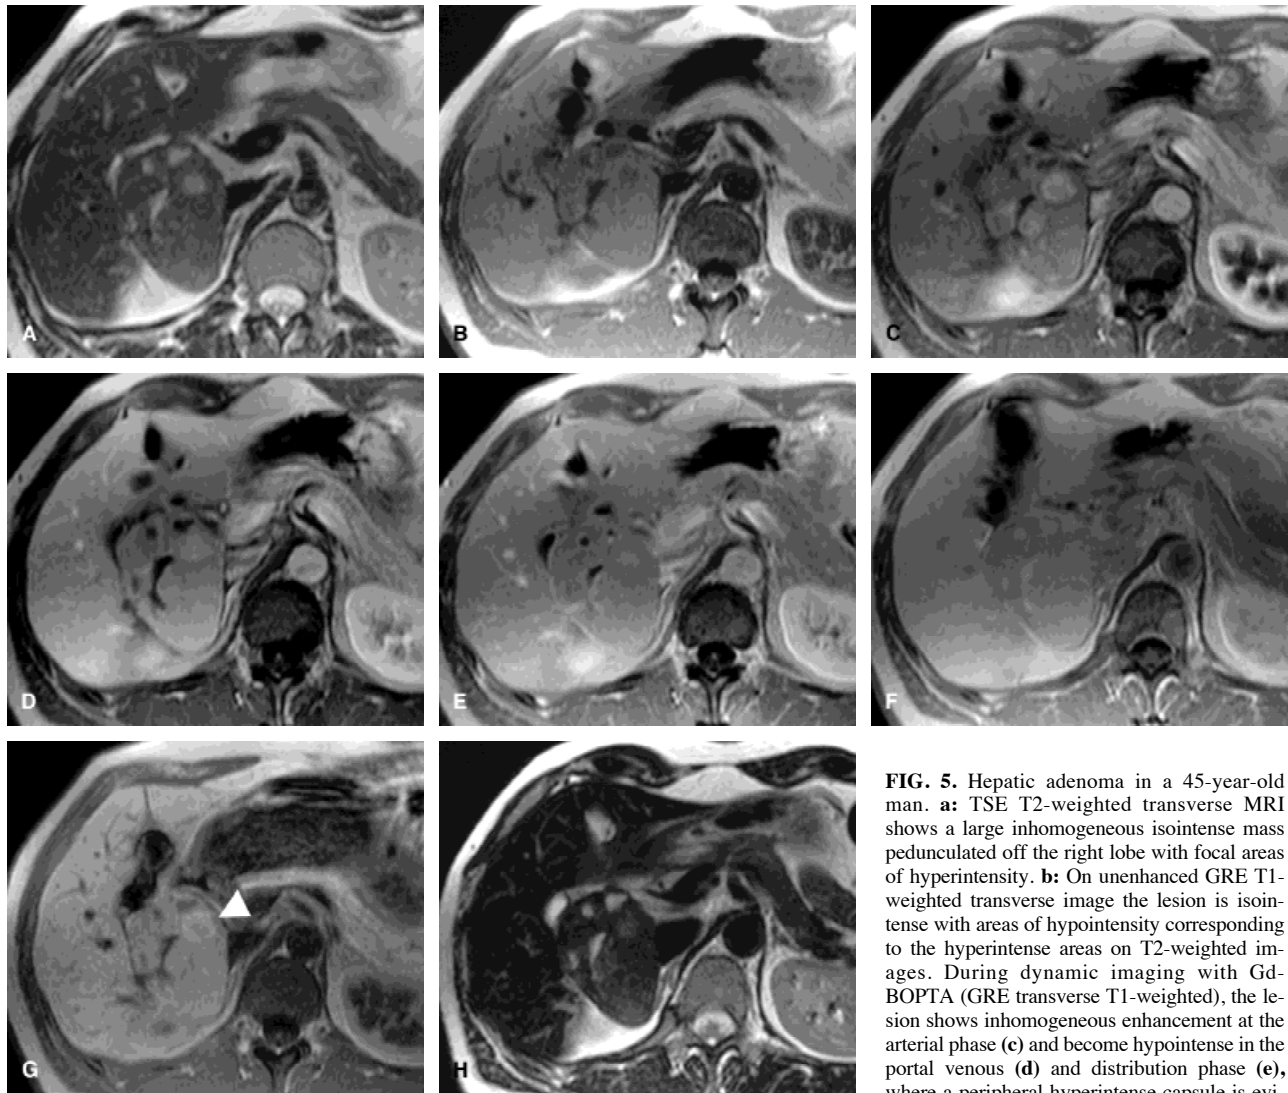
Hepatic adenoma in a 45-year-old man. a: TSE T2-weighted transverse MRI shows a large inhomogeneous isointense mass pedunculated off the right lobe with focal areas of hyperintensity. b: On unenhanced GRE T1-weighted transverse image the lesion is isointense with areas of hypointensity corresponding to the hyperintense areas on T2-weighted images. During dynamic imaging with Gd-BOPTA (GRE transverse T1-weighted), the lesion shows inhomogeneous enhancement at the arterial phase (c) and become hypointense in the portal venous (d) and distribution phase (e), where a peripheral hyperintense capsule is evident. f: GRE transverse T1-weighted image at
